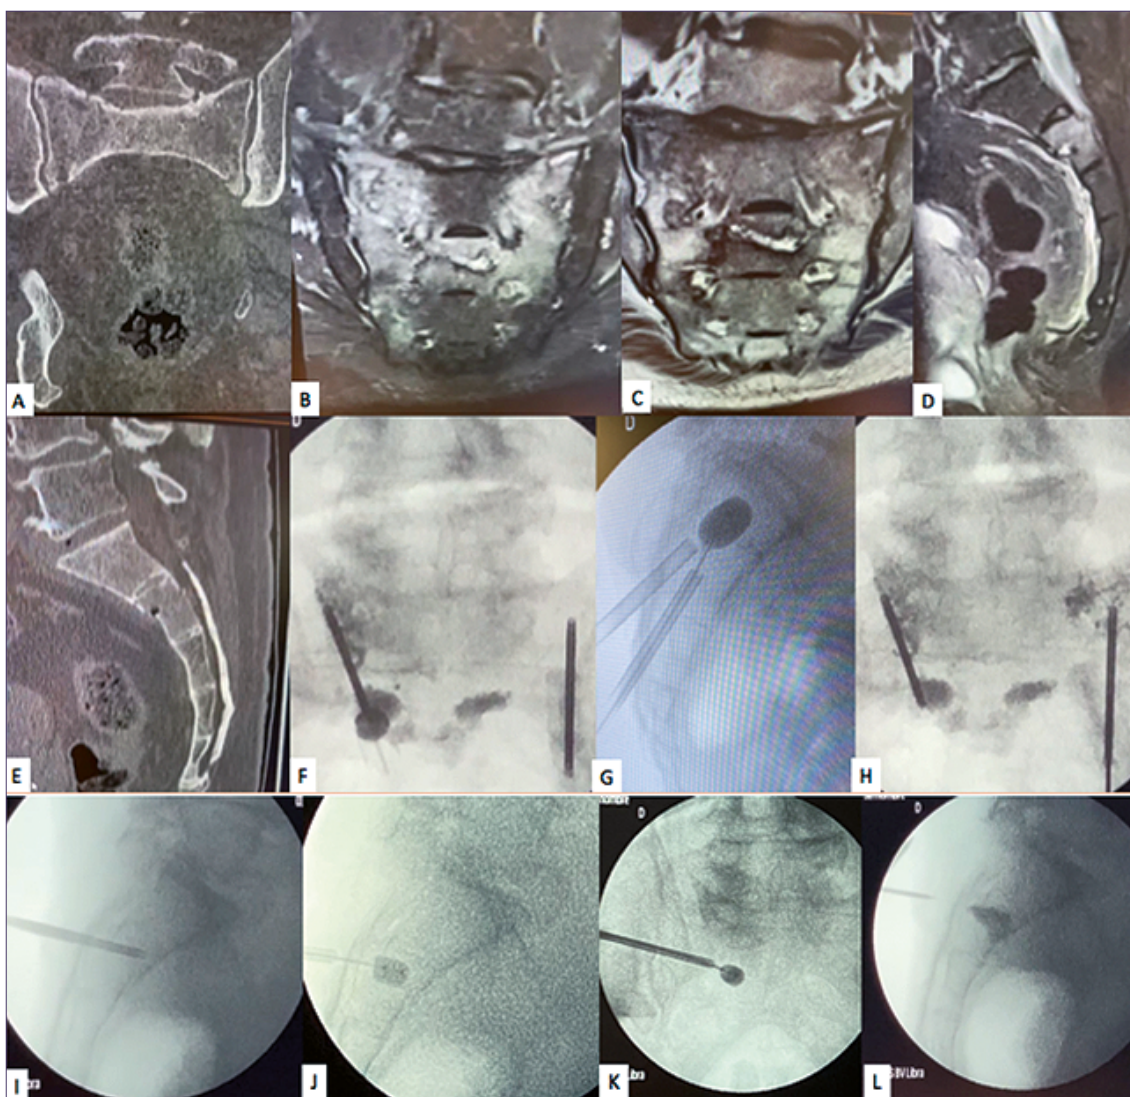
Preoperative evaluation and intraoperative follow-up of percutaneous sacroplasty. A: Coronal computed tomography (CT): bilateral vertical fractures in the sacral wings; B-D: Magnetic resonance imaging (MRI): diffuse bone edema compatible with insufficiency fractures; Coronal section in B and C, sagittal section in D with edema in S2; E: Sagittal CT: evident fracture line in the body of S2; F: Fluoroscopic control: bilateral cementation in S2 and vertebroplasty in right S1; G: Sagittal fluoroscopy: balloon kyphoplasty, evidence of expansion, and trajectory of two trocars (one through the S2 foramen, the other at the S2-S3 junction); H: Post-injection control: vertebroplasty completed in the left sacral ala; I: Lateral fluoroscopy: trocar positioned within the body of S2; J-K: Balloon inflation (J: lateral; K: AP) to create a cavity prior to filling; L: Controlled introduction of PMMA cement under fluoroscopic guidance.
